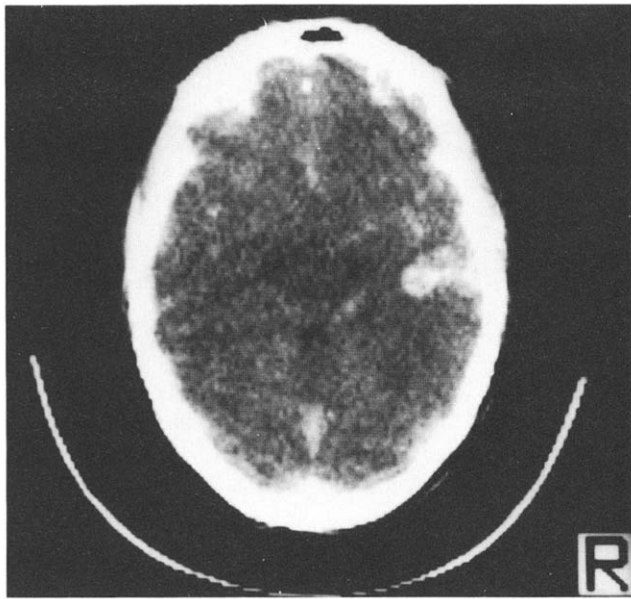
CT scan of patient on admission, showing right frontal and parietal enhancement.
